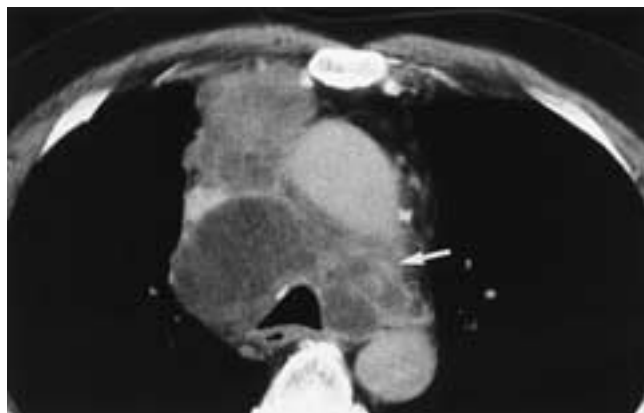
Small cell carcinoma with mediastinal nodes. Axial CT scan demonstrates enlarged anterior mediastinal, pretracheal retrovascular, and AP window nodes. The nodes in the AP window (*arrow*) are responsible for the patient's vocal cord paralysis.
